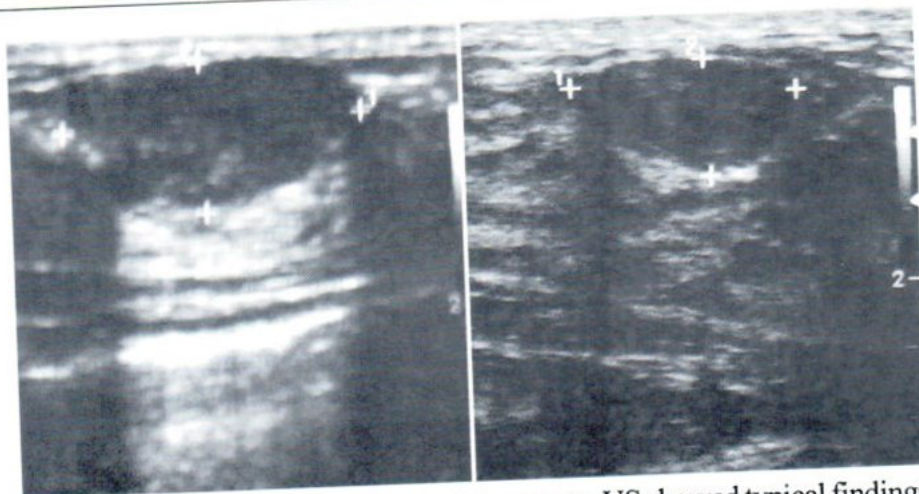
Two patients in the BI-RADS 2 category. US showed typical findings of benign masses: oval shape, well-circumscribed, hypoechoic, abrupt boundary and posterior enhancement. US : Ultrasonography
